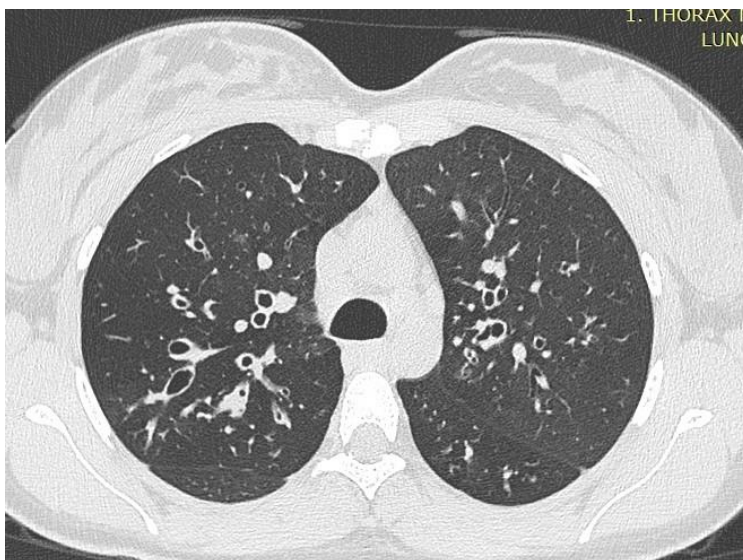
HRCT scan through the upper lobes of an individual with cystic fibrosis showing cylindrical bronchiectasis and bronchial wall thickening.
